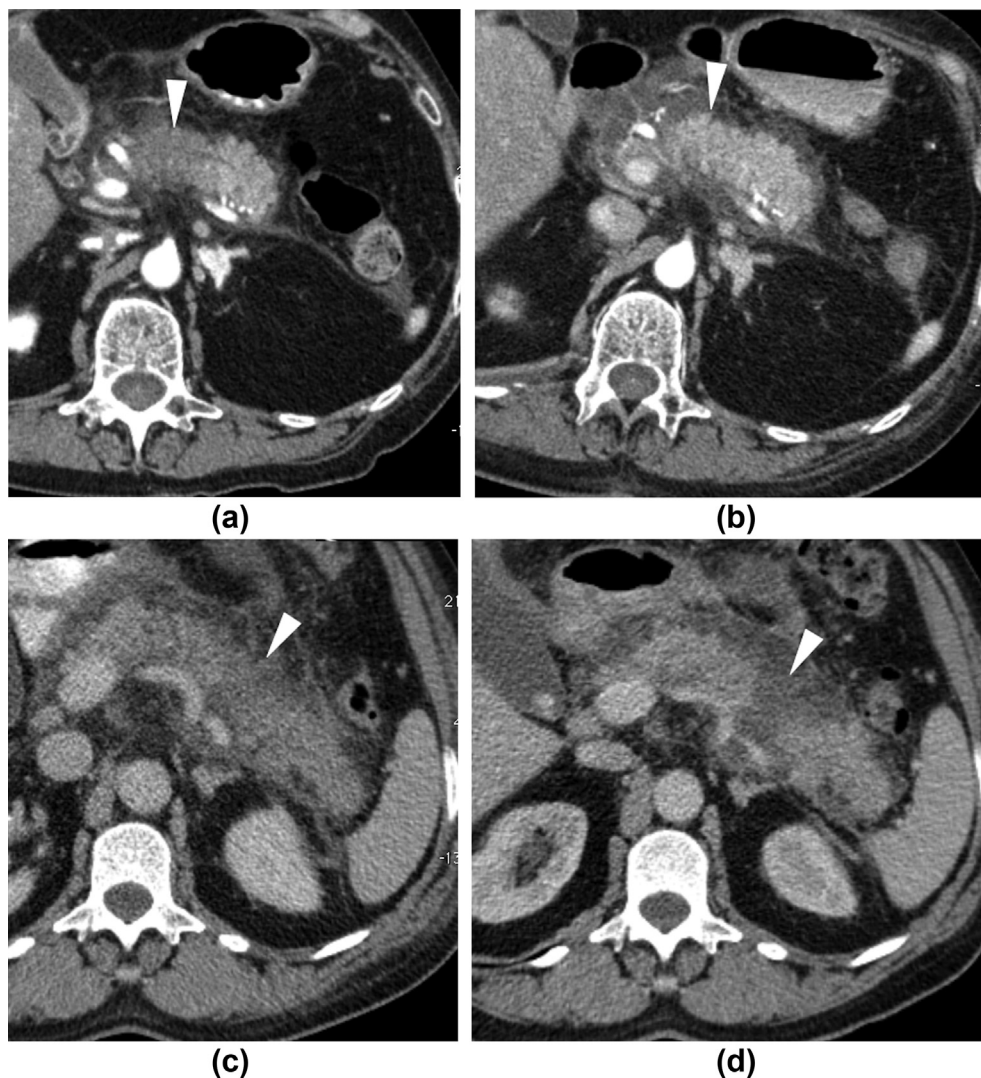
(a–b) False-positive parenchymal necrosis. (a) Early contrast-enhanced CT demonstrates a focal hypodense area at the pancreatic neck and proximal body (arrowhead). (b) Follow-up CT 5 days later shows normal perfused pancreas (arrowhead). (c–d) False-negative parenchymal necrosis. (c) Early contrast-enhanced CT depicts a slightly hypodense area at the body–tail junction (arrowhead), which was not read as parenchymal necrosis in the original report. (d) Follow-up CT 1 week later shows an area of non-enhancement at the body–tail junction (arrowhead) compatible with <30% parenchymal necrosis.
